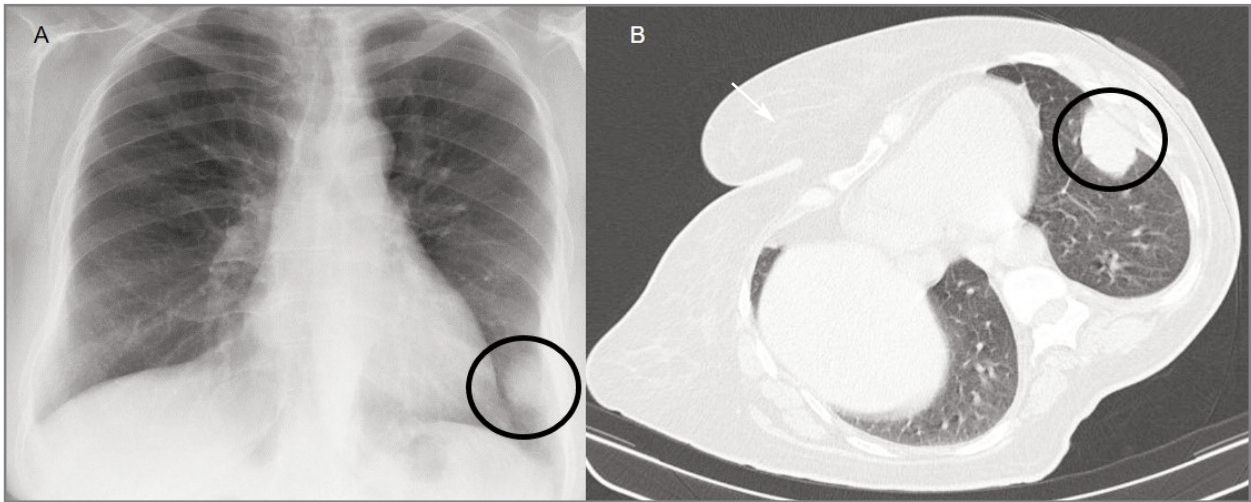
Chest X-ray (A) and computed tomography (B) showing a subpleural nodule at the left lower lobe
